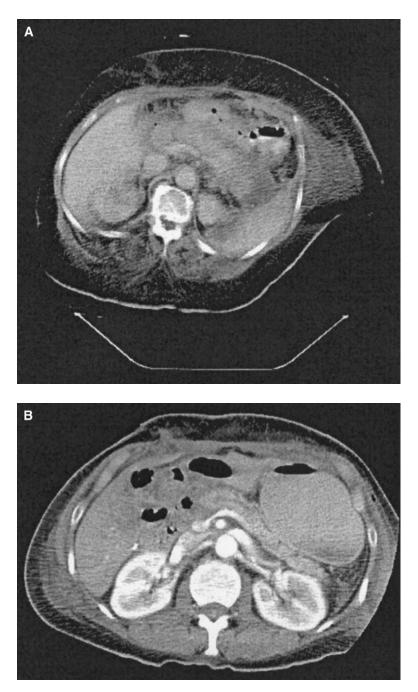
(A) Patient with postoperative pancreatitis. (B) Normal postoperative CT.
